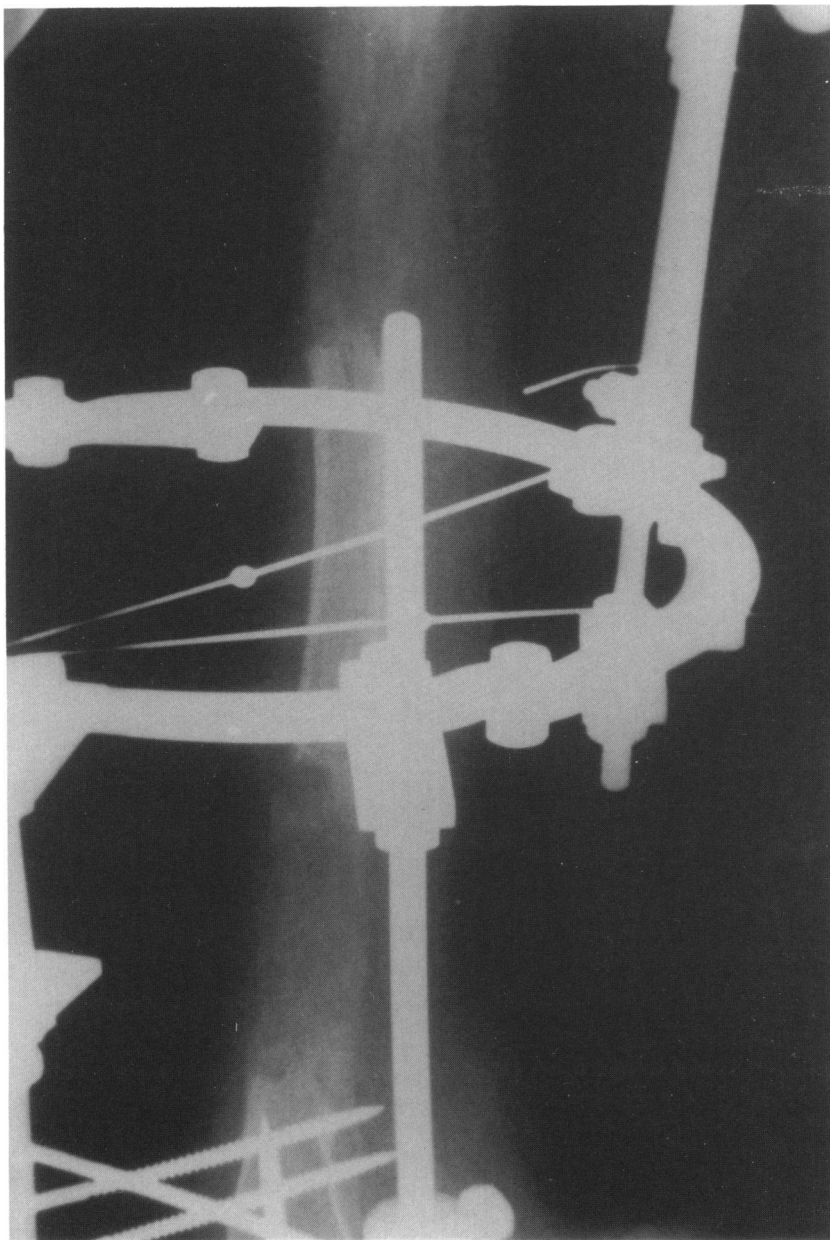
X-ray shows lengthened segments during the procedure. Reproduced by permission from Atar, D. et al.: Treatment of complex limb deformities in children with the Ilizarov technique. *Orthopedics* 14(9): 961-67, 1991.
